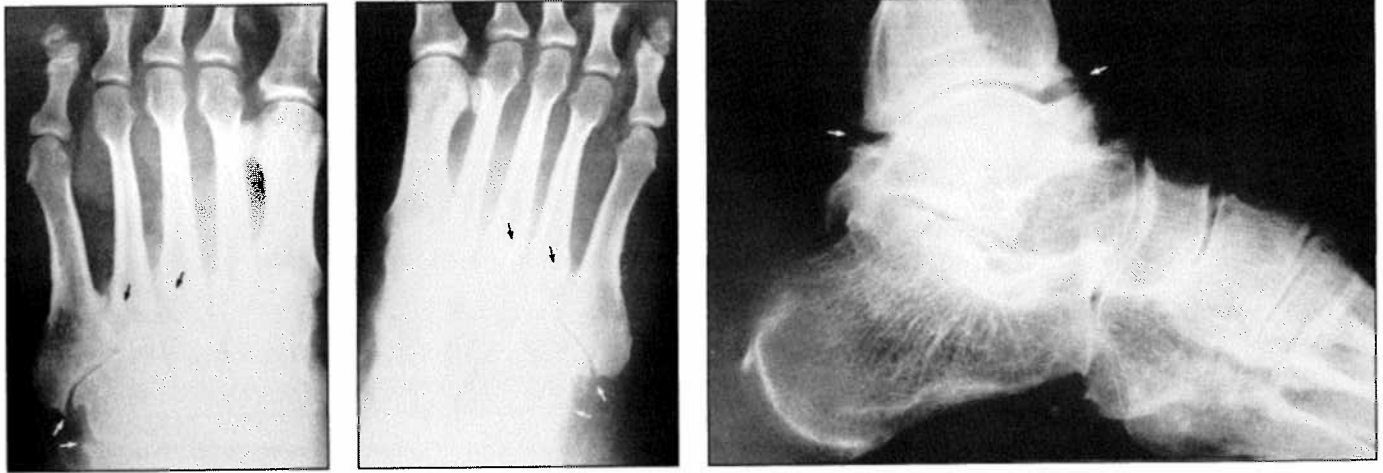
and 7 Radiographic exam of the ankle and foot in a 28-year old man with gout. The black arrows demonstrate the erosive changes at the metatarsal bases characteristic of gout. The white arrows point to the osteophytes.
